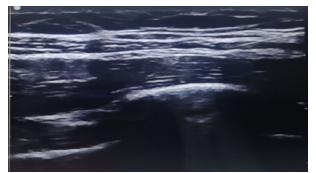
ultrasound scan of serratus anterior muscle block pre injection of local anesthetic agent.
